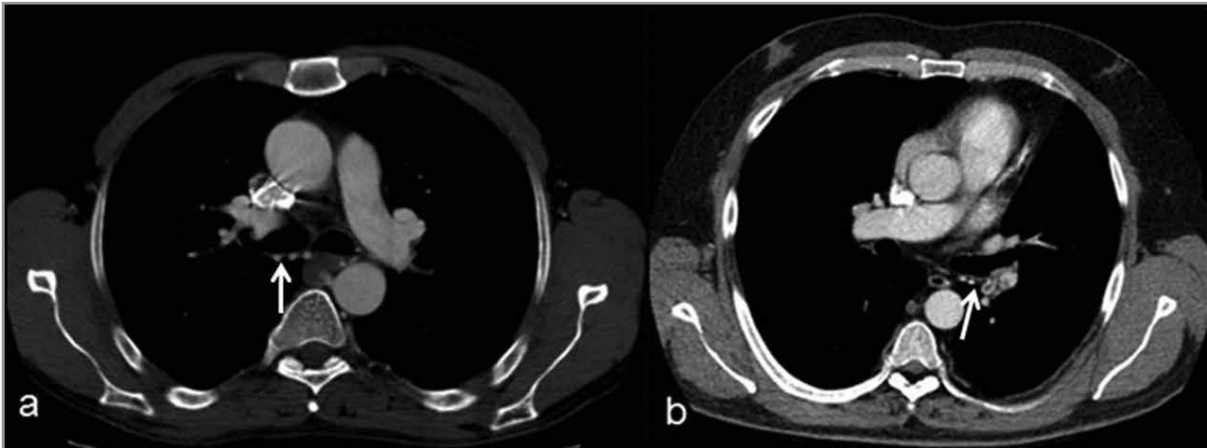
Axial sections from mediastinum in pulmonary CTA are demonstrating hypertrophied bronchial artery (arrows) in two BD patients (a and b), diagnosed as pulmonary arter thromboembolism (PAT).
